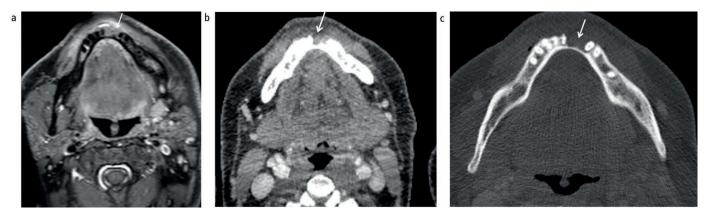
MRI and CT of anterior mandible gingival SCC. (a) Axial post-gadolinium enhanced fat-suppressed T1-weighted image shows enhancing lesion (arrow) invading into the medullary cavity of mandible alveolar bone. The lesion is also depicted than on the axial contrast enhanced CT image (b). (c) High resolution bone-weighted CT depicts well the bony cortical destruction and erosion (arrow)
